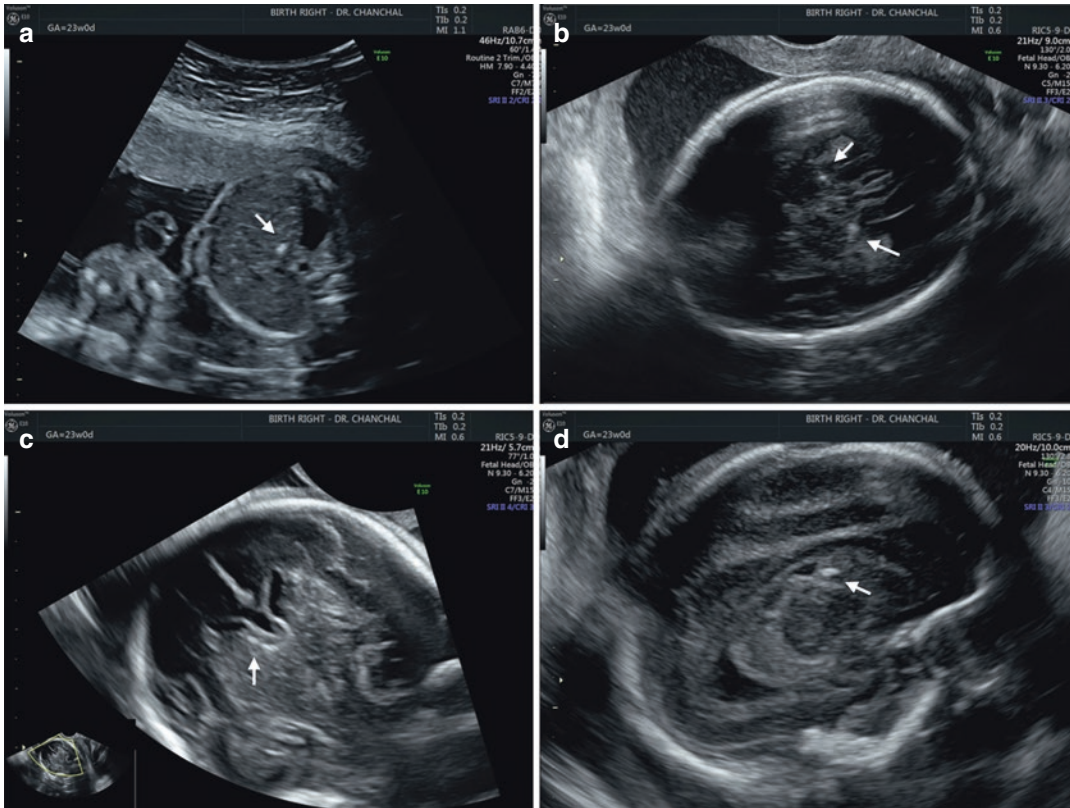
(a) Transabdominal 2D ultrasound showing hepatic calcification (b–d) Transvaginal 2D ultrasound images showing intracerebral and periventricular calcifications in a fetus with CMV infection (CMV PCR positive on amniotic fluid)
